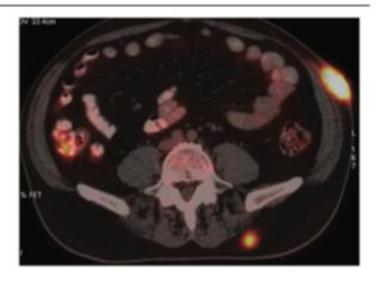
T cell cutaneous lymphoma showing intense FDG uptake in a skin lesion and subcutaneous nodules in a 62-year-old man.
